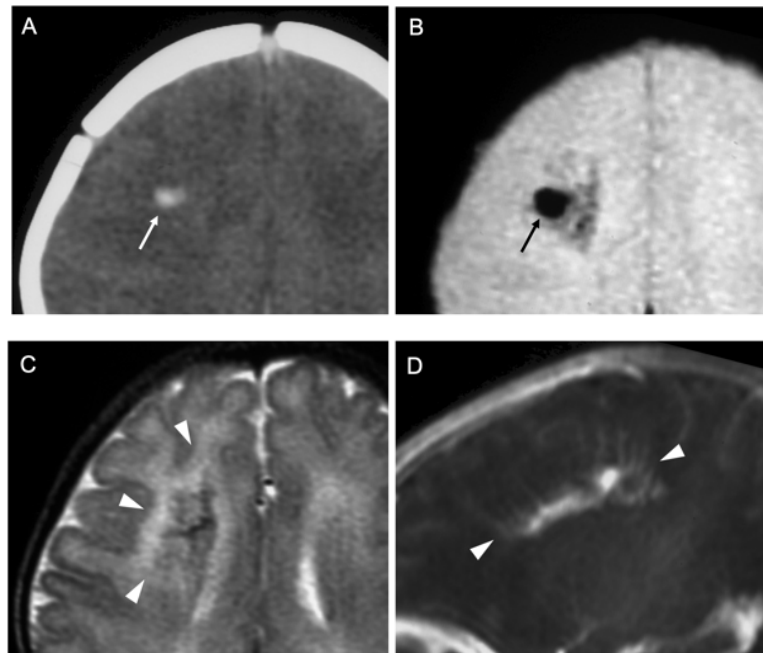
Neonatal developmental venous anomaly complicated by focal hemorrhage and diffuse WM signal abnormalities likely related to venous congestion. A) Unenhanced head CT scan demonstrates a focal area of spontaneous hyperdensity (*white arrow*) in the right frontal region, suggestive of recent hemorrhage. Corresponding axial gradient echo T2*-weighted image (B) and T2WI (C) show a blooming artifact (*black arrow*) in the region corresponding to the hemorrhage, that subsequently regressed (not shown), and diffuse hyperintensity of the surrounding WM (*arrowheads*) in keeping with venous congestion. D) Sagittal contrast-enhanced T1WI reveals a large developmental venous anomaly characterized by several radially-oriented dilated veins with a *caput medusae* morphology and deep venous drainage (*arrowheads*).
